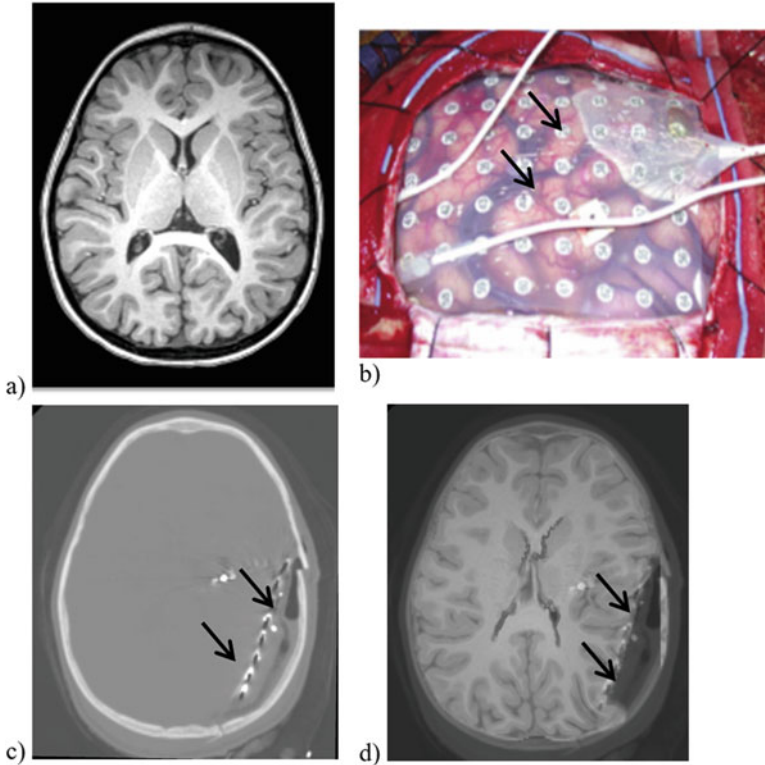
(a) Pre-operative MRI, (b) intra-operative photograph of implanted intracranial electrodes (pointed by arrows), (c) intra-operative CT with electrodes implanted and (d) pre-operative MRI registered onto intra-operative CT. In this chapter we explain how to obtain image 1D using computational biomechanics of the brain. These are two-dimensional sections of three-dimensional image volumes. We have successfully registered four cases [12]
